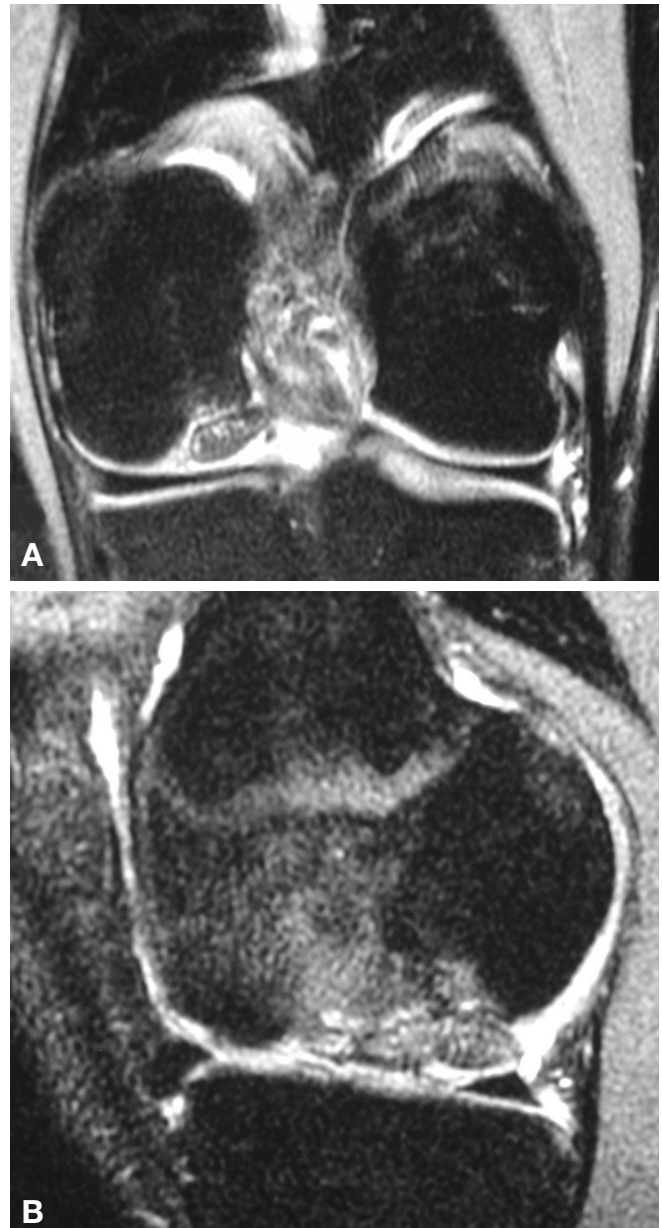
An MRI of osteochondritis dissecans on lateral aspect of medial femoral condyle, (A) coronal view and (B) sagittal view, demonstrating fluid dissection behind the base of the lesion.
